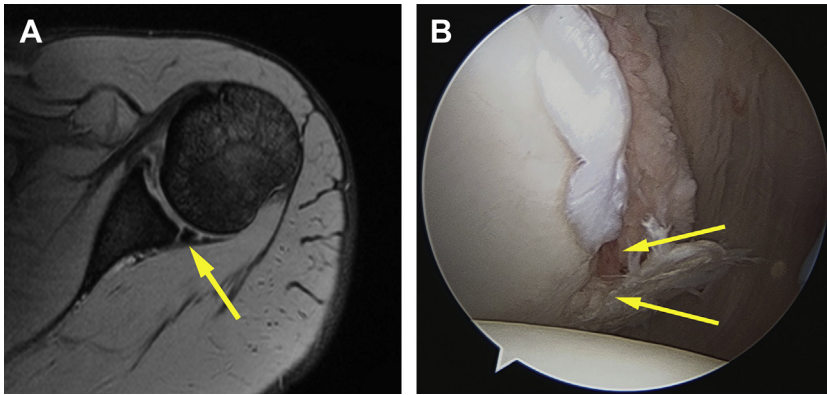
Magnetic resonance image showing disruption of the posteroinferior glenoid labrum (arrow, A). Arthroscopic image confirming discontinuity of the glenoid surface and the posterior labrum (arrows, B).
